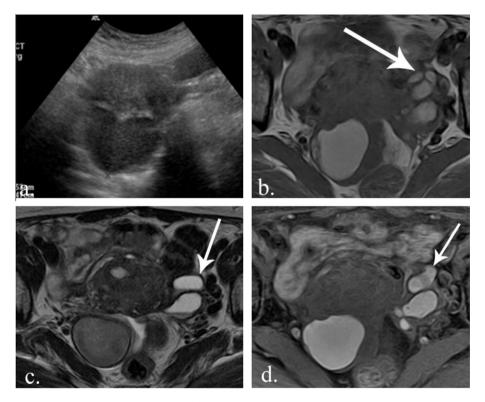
Endometriosis: a 38 year old female presented with pelvic pain and dysmenorrhea. (a) Pelvic ultrasound revealed cystic mass in the right adnexal region with diffuse low-level internal echoes. (b) Axial T1 fat sat. revealed that this cystic mass is an endometrioma displaying hyperintense signal on T1 weighted images with and without fat suppression (b & d) with hypointense signal on T2 weighted image (c) denoting its hemorrhagic nature. Also noted are multiple left adnexal confluent cystic lesions bright on T1 weighted images with and without fat suppression (b & d). Some fluid levels on T2 weighted image(c) were noted denoting left sided hematosalpinx (arrows).
